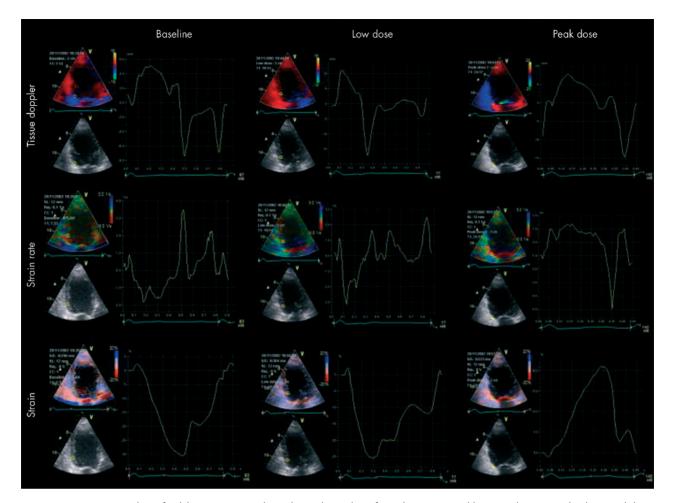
Quantitative analysis of a dobutamine stress echocardiographic study performed in a 53 year old patient who presented with atypical chest pain. Baseline, low dose, and peak dose dobutamine infusion have been recorded using colour high frame rate TDE. Strain rate and strain images were obtained and analysed off-line. The region of interest was located in the inferobasal segment where visual interpretation of changes in wall thickening and endocardial motion proved difficult. At baseline, lowid dose, systolic strain rate, and strain profiles showed a normal pattern with peak systolic velocity 5 cm/s, peak systolic train rate -1.9 s^{-1} , and peak systolic strain -30%. During low dose dobutamine infusion, TDE velocity and deformation rate increased. Peak systolic TDE velocity was 11 cm/s and peak systolic strain rate was -3.1 s^{-1} . In contrast, peak systolic strain mildige decreased to -25%. During peak dose dobutamine infusion, peak systolic TDE velocity was reduced to 7.8 cm/s. The basal inferior region showed longitudinal expansion in systole with inverted and positive peak systolic strain rate $+1.2 \text{ s}^{-1}$ followed by pronounced negative strain rate during isovolumic relaxation (post-systolic shortening). Systolic strain was clearly positive as opposed to baseline and low dose dobutamine profiles. This segment, therefore, became ischaemic at peak stress and showed a biphasic response during incremental doses of dobutamine.
